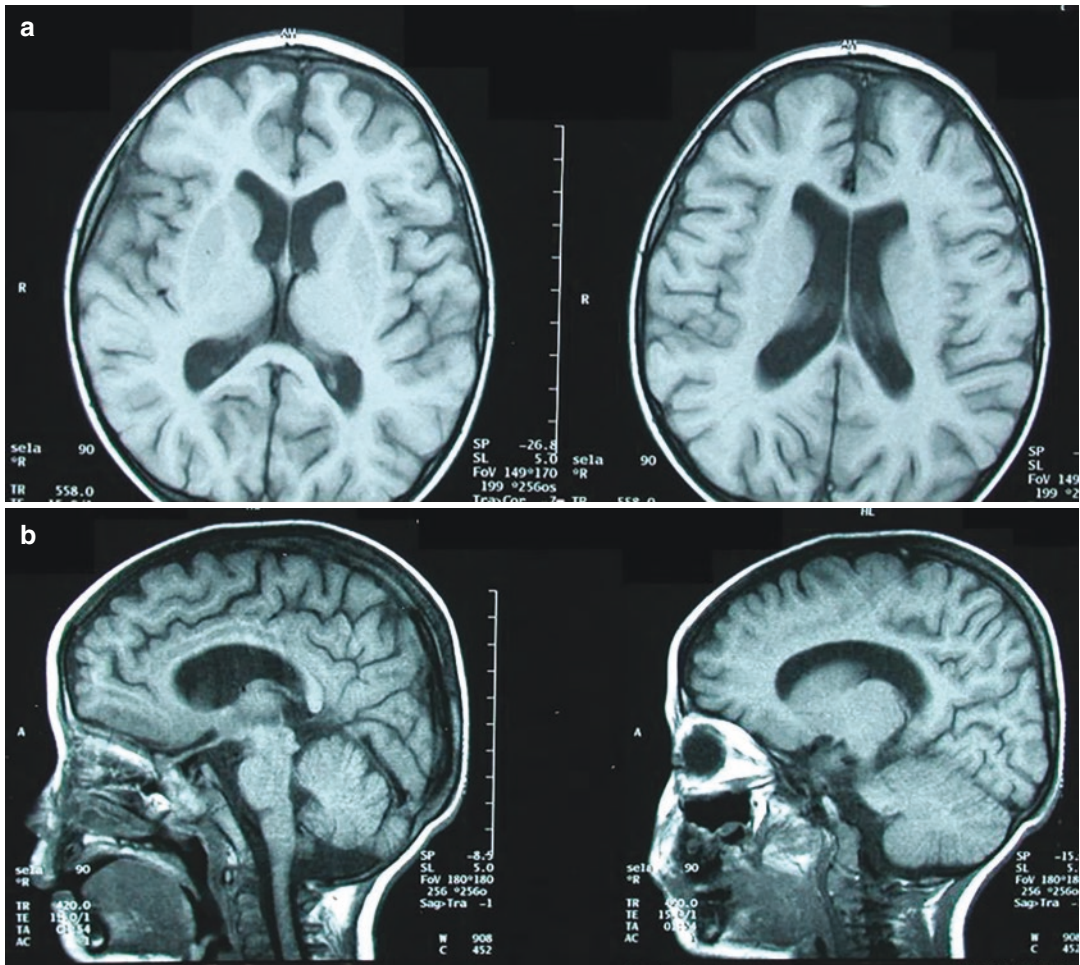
On hospital day 22, the magnetic resonance imaging (MRI) of brain in Case 2 showed diffused cerebral atrophy in the axial view (a) and coronal view (b)
